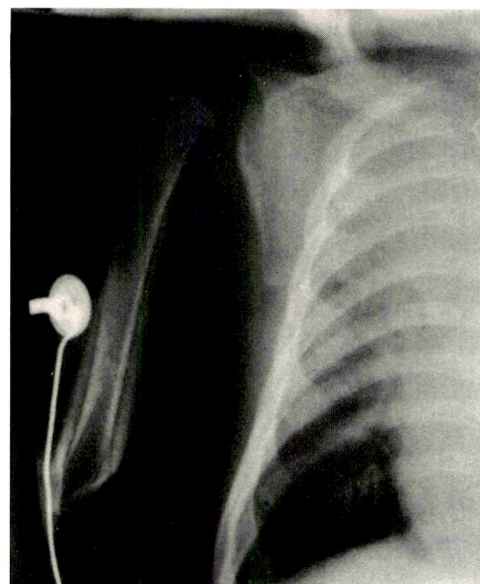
Hyperostosis associated with prostaglandin E₁ (PGE₁) therapy. Chest radiograph obtained after 2 months of IV PGE₁ therapy in neonate with ductus-dependent cyanotic congenital heart disease shows periosteal new bone cloaking ribs, humeral shafts, and scapulae. (Courtesy of J. Marquis, Newark, NJ.)
